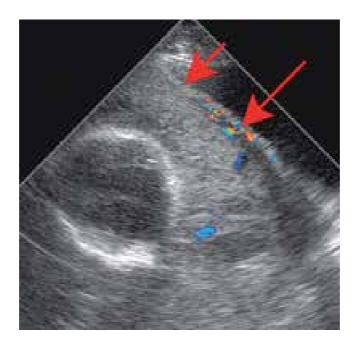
Colour Doppler image demonstrating absence of intervening myometrium (short arrow) and abnormal bladder–uterine wall vascularisation (long arrow). Courtesy of Callen P of a posterior placenta accreta, with or without placenta praevia, ultrasonography may be insufficient. In general, MRI may better outline the anatomy and degree of invasion (Figure 10) [54].
